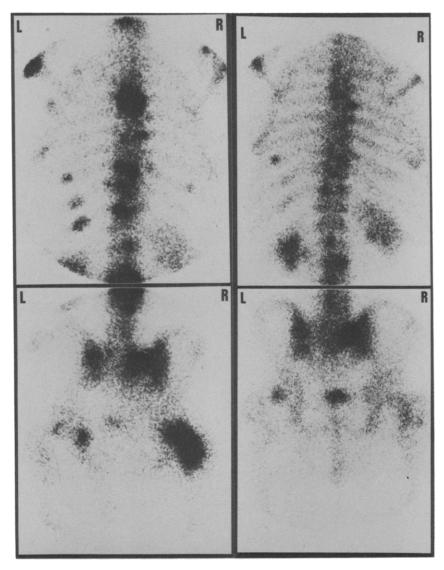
Bone scintigraphy before treatment (left) and 6 months after start of treatment (right) in patient 1.
